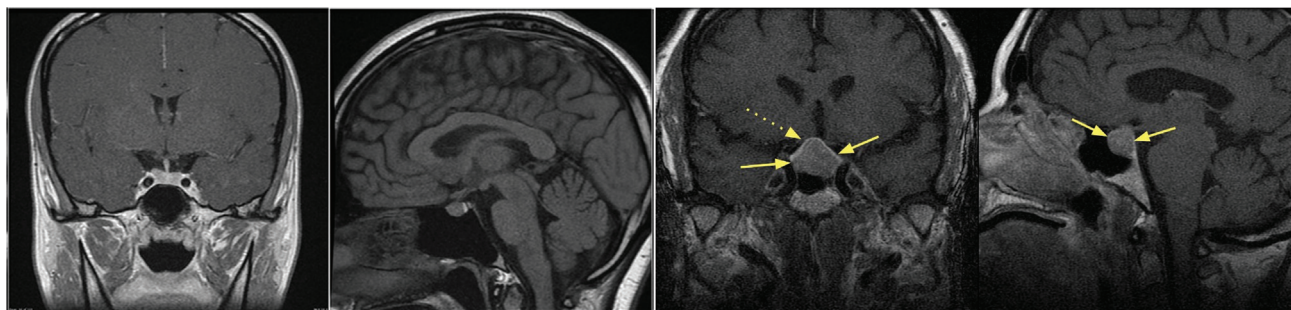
MRI pituitary showing a normal pituitary gland in the left two panels and a pituitary macroadenoma in the right two panels.
